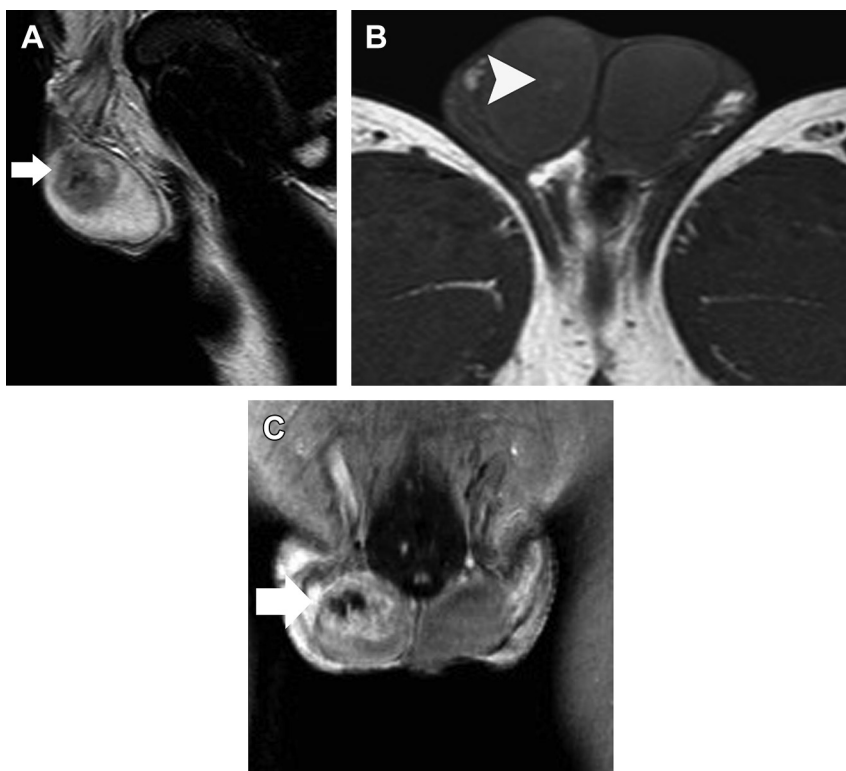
Embryonal carcinoma confined to the right testis (pT1) in a 26-year-old man. (A) Sagittal T2-weighted image shows heterogeneous intratesticular tumor (*arrow*) surrounded by a rim of normal testicular parenchyma. (B) Axial T1-weighted image depicts small hyperintense area within the mass (*arrowhead*), corresponding to area of hemorrhage. (C) Coronal DCE image shows strong, heterogeneous tumor enhancement (*arrow*). Imaging findings are suggestive of nonseminomatous tumor.
